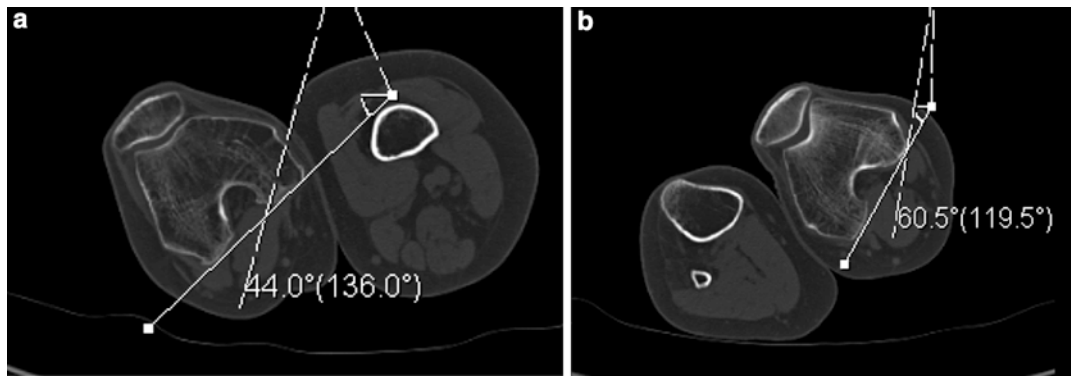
(a, b) CT rotational profile of bilateral lower extremities was obtained preoperatively. Calculations demonstrated 40° of external rotation and 40° of internal rotation of the right and left femurs, respectively. In addition, right tibia 15° external rotation
